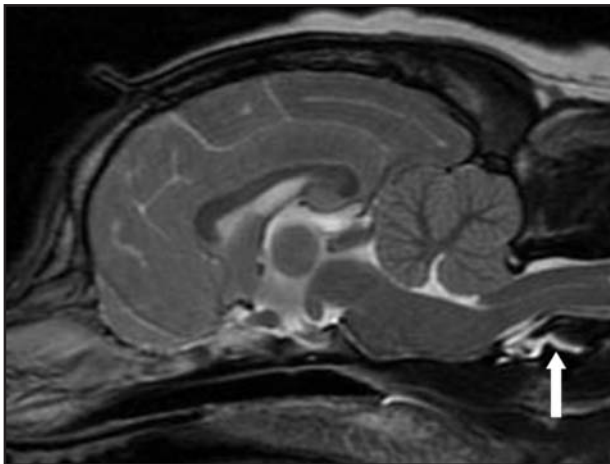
Cranial midsagittal T2-weighted MR image including the brain and cervical aspect of the spinal cord of a CKCS. The dorsal angulation of the dens is causing a kinked appearance of the cervicomedullary region and effacement of the ventral aspect of the subarachnoid space (arrow).
